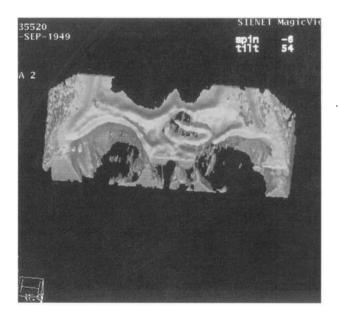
3D CT reconstruction demonstrating structure of sinolith.
